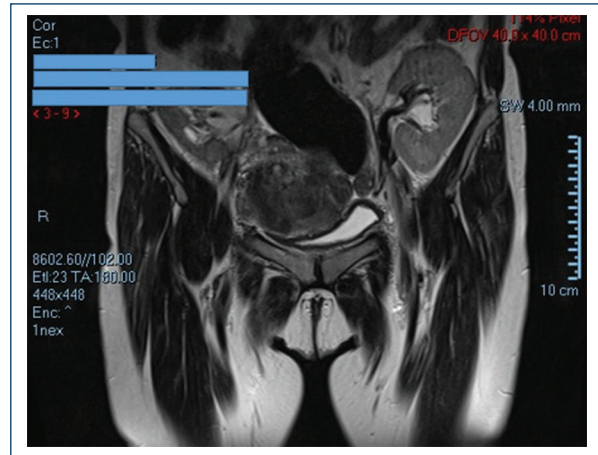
Abdominal magnetic resonance imaging with evidence of two kidney grafts in the pelvic location.
